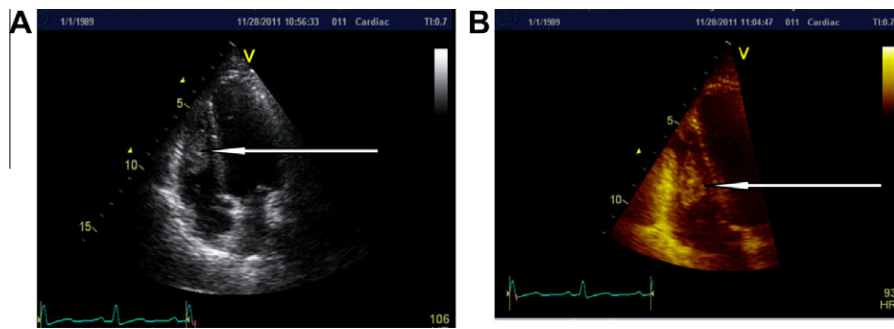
Transthoracic echocardiography showing RV mass. (A) Without and (B) with color superimposition.
